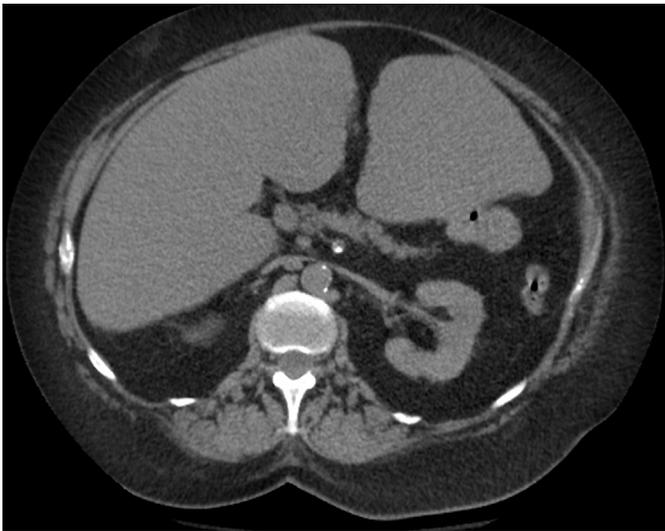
Axial non-contrast abdominal/pelvic CT showing a mildly atrophic pancreas with no demonstrable mass, no obvious intra- or extrahepatic biliary dilatation, no evidence of cholecystitis or ascending cholangitis, and no intrahepatic abnormality.
